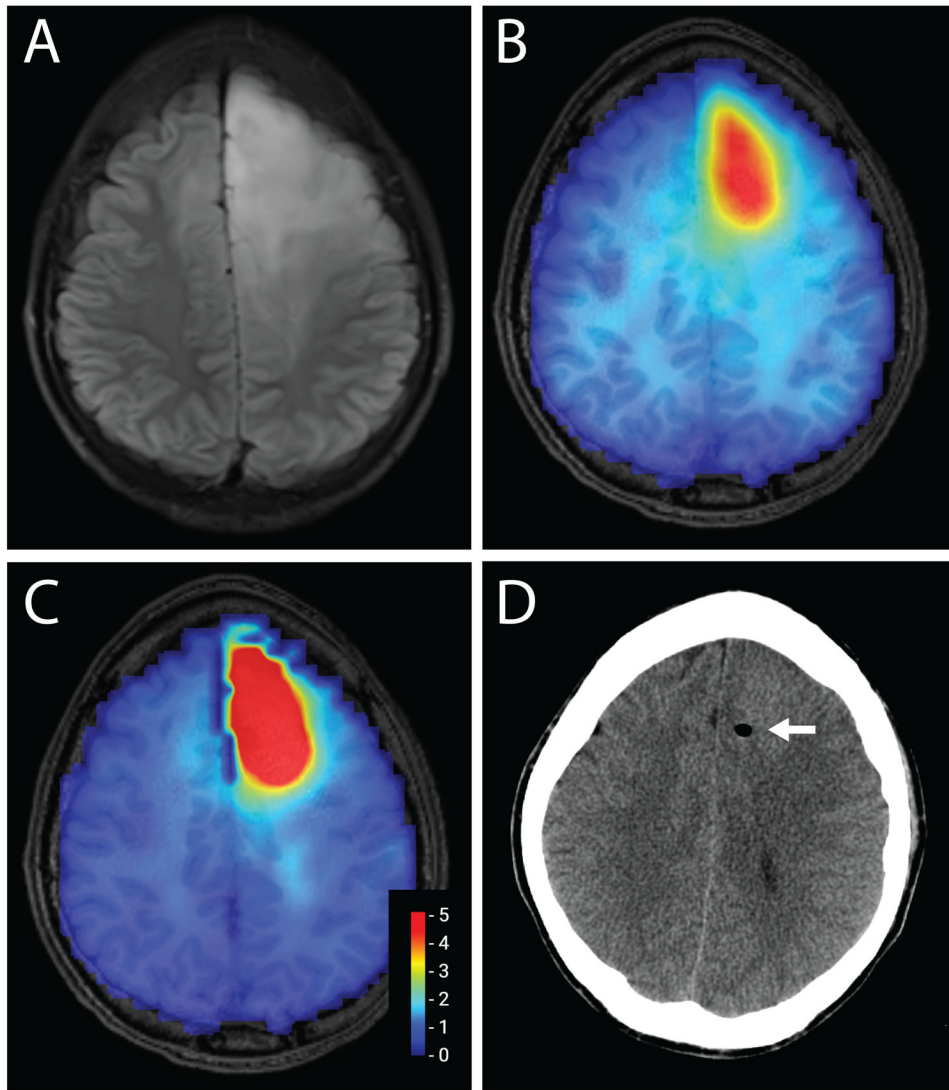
Grade 3 astrocytoma. 31 year-old man with a left frontal expansile, non-enhancing mass seen on FLAIR (A). T1-weighted images overlaid with 3D Cho map (B) and Cho/NAA ratio (C), showing areas of greatest metabolic abnormality. Scale in (C) shows the ratio between Cho/NAA and normal white matter. Stereotactic biopsy was targeted to a region with maximal metabolic abnormality, as seen on post-biopsy CT (D).
